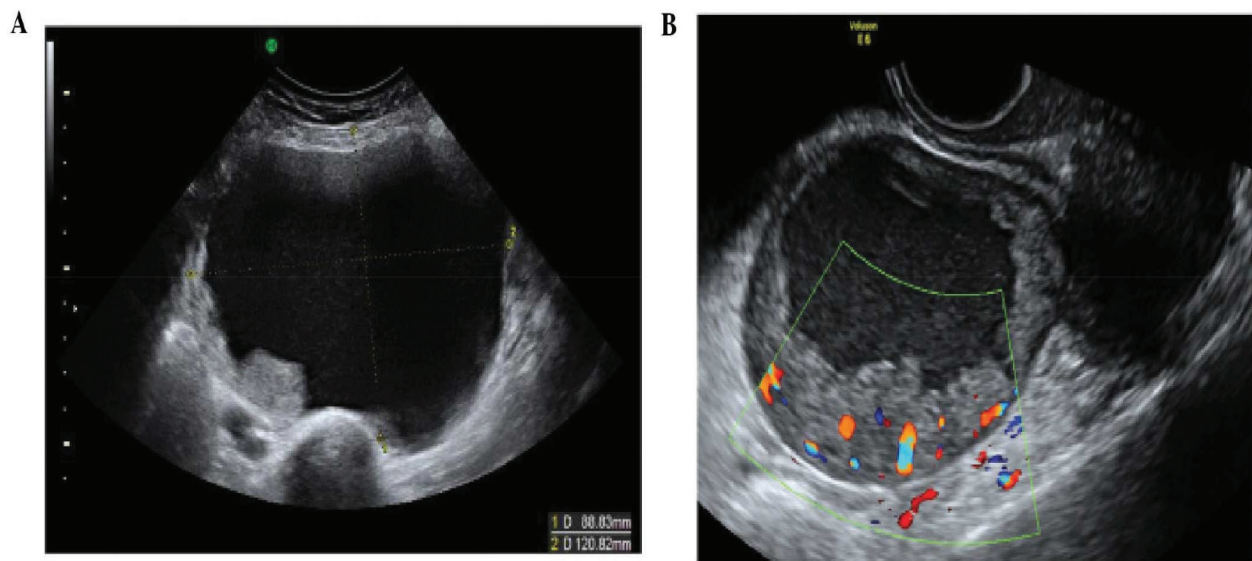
Primary invasive ovarian epithelial cancers. (A) Stage 1, clear cell carcinoma of the ovary. (B) Unilocular solid early invasive cancer with increased vascularity on color Doppler.
